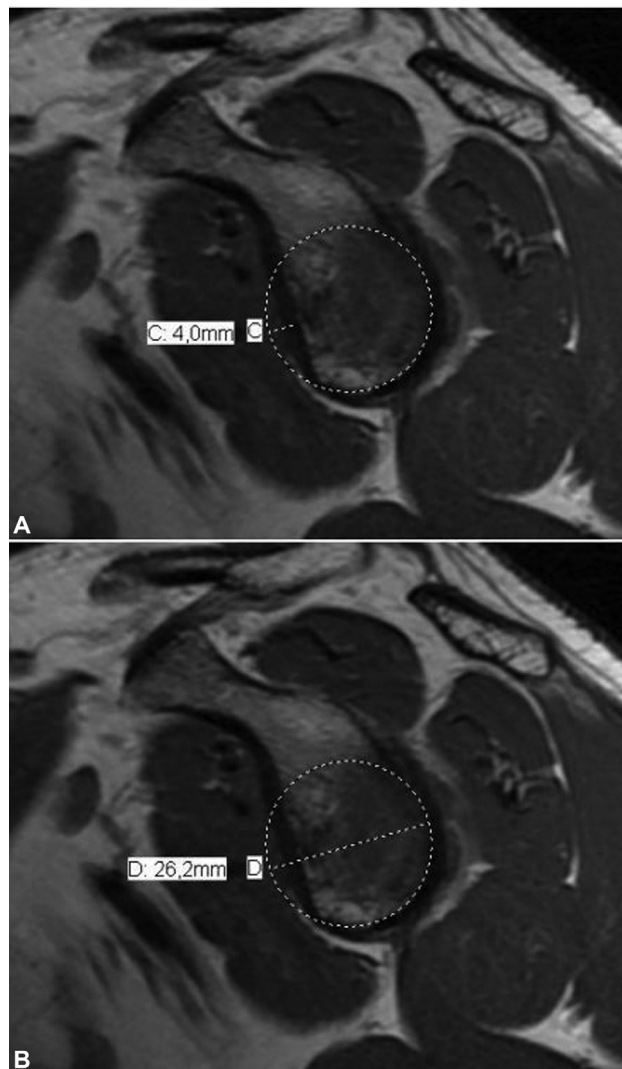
Measurement of the anterior defect of the glenoid was performed by the perfect circle method in modified sagittal slice of the more lateral portion of glenoid on magnetic resonance imaging. The diameter of the glenoid (D) and the bone defect (C); calculation of the percentage of the anterior bone defect of the glenoid, using the formula: bone defect of the glenoid (%) = C/D.
